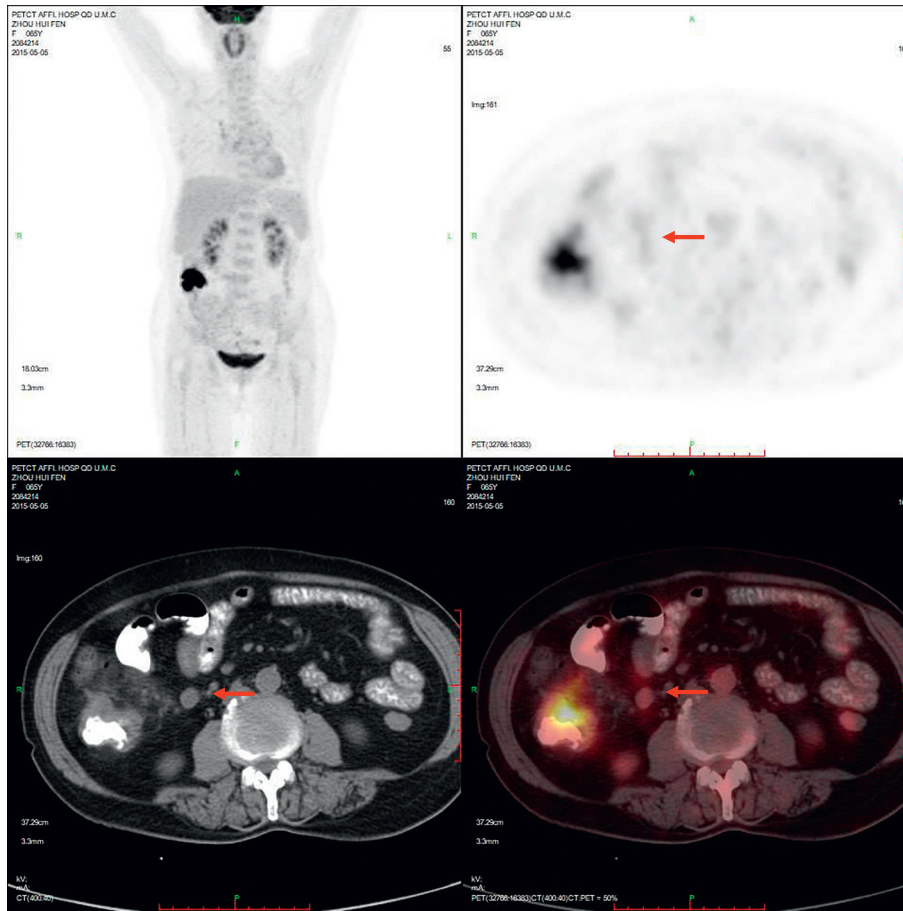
Female, 65 years old, colon cancer (SUVmax, 17.0). The SUVmax of enlarged lymph nodes beside the right colon (10 \* 11 mm) is about 4.6.
